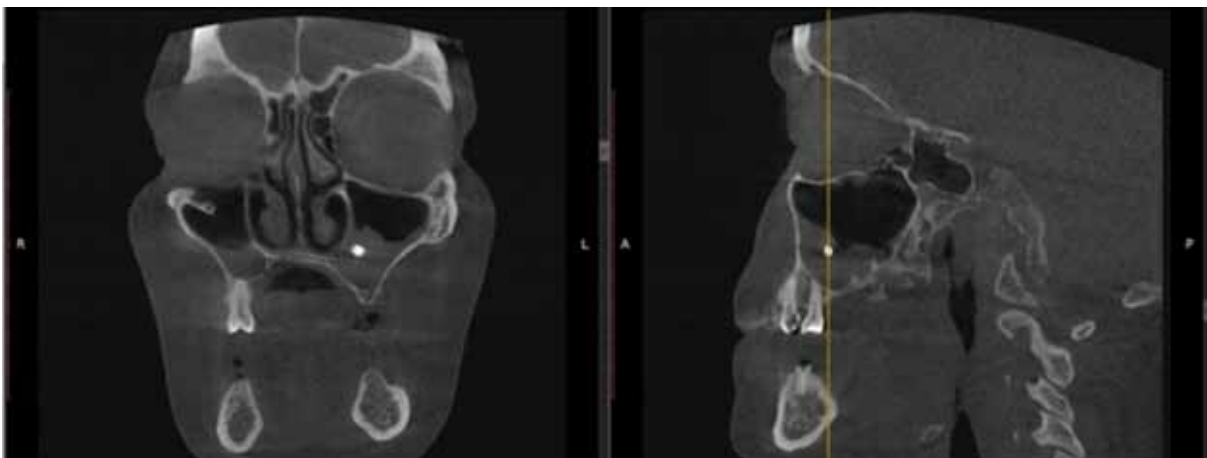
Reformat of cone-beam computed tomography of a patient diagnosed with the presence of a foreign body in the maxillary sinus
